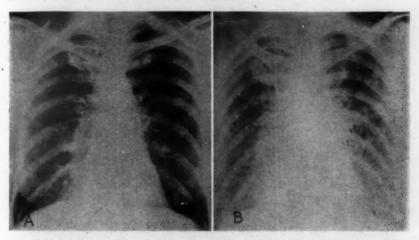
(case 2).—A, roentgenogram of the chest taken on admission. It shows finely mottled densities extending from the right hilus.
